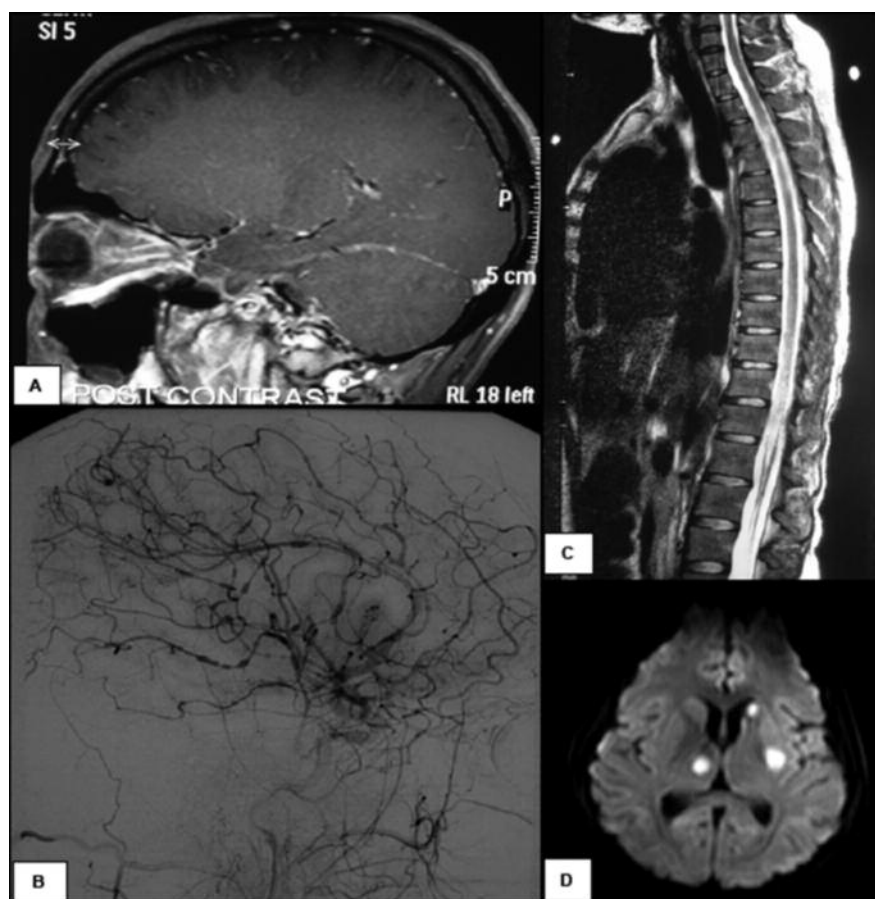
A. Sagittal T1 post-gadolinium MRI showing enhancement of optic nerve sheath. B. Right common carotid cerebral angiogram showing extensive beading and variation in calibre of cerebral arteries consistent with severe cerebral vasculitis. C. Sagittal T2 weighted spinal cord MRI with prolongation of T2 signal throughout the thoracolumbar cord. D. Diffusion weighted MRI from day 71 showing three acute infarcts.
